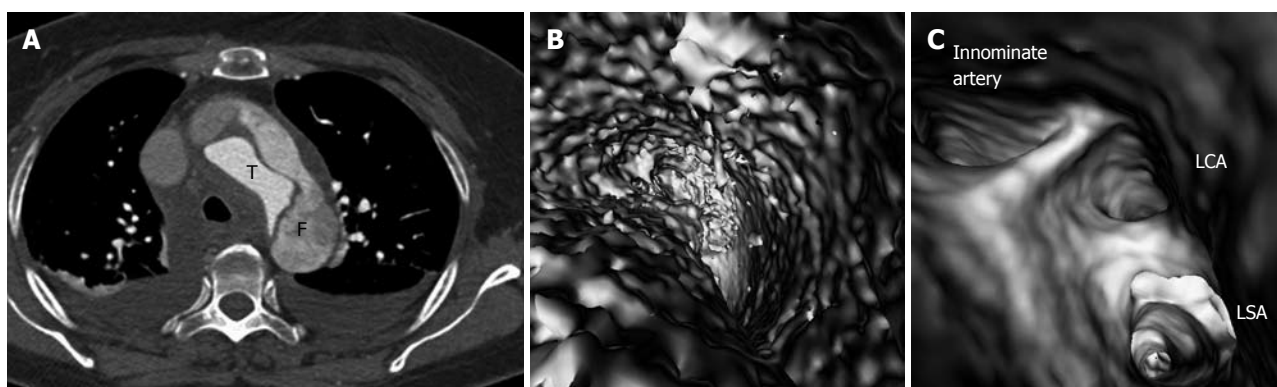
Stanford type A dissection with the true lumen smaller than the false lumen. The false lumen (F) has lower computed tomography (CT) attenuation than that in the true lumen (T) due to thrombus formation (A), thus a lower CT threshold (90 HU) was applied to view the false lumen intraluminally (B), while a higher CT attenuation (300 HU) was applied to demonstrate the true lumen. Corresponding virtual intravascular endoscopy (C) shows the involvement of three aortic branches by the dissection, namely left subclavian artery (LSA), left common carotid artery (LCA) and innominate artery when the view is positioned inside the false lumen. Bilateral pleural effusion is present on the 2D axial image.
